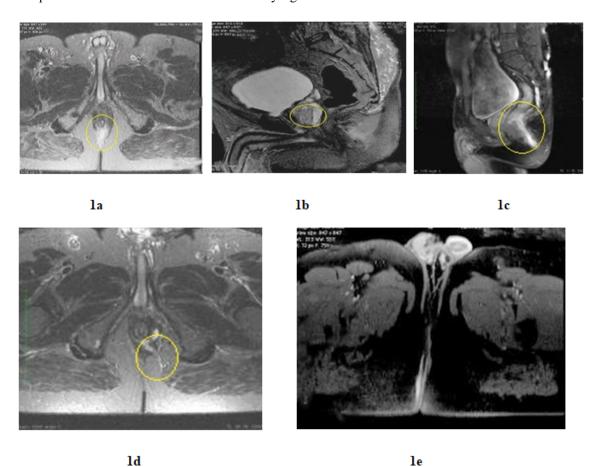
MRI images representing St James grading of fistulas in the study cases. 1a- Grade 1 simple linear intersphincteric fistula, 1b- Grade 2 intersphincteric fistula with abscess, 1c- Grade 3 transsphincteric fistula, 1d- Grade 4 transsphincteric fistula with abscess, 1e- Grade 5 supralevator and translevator disease
